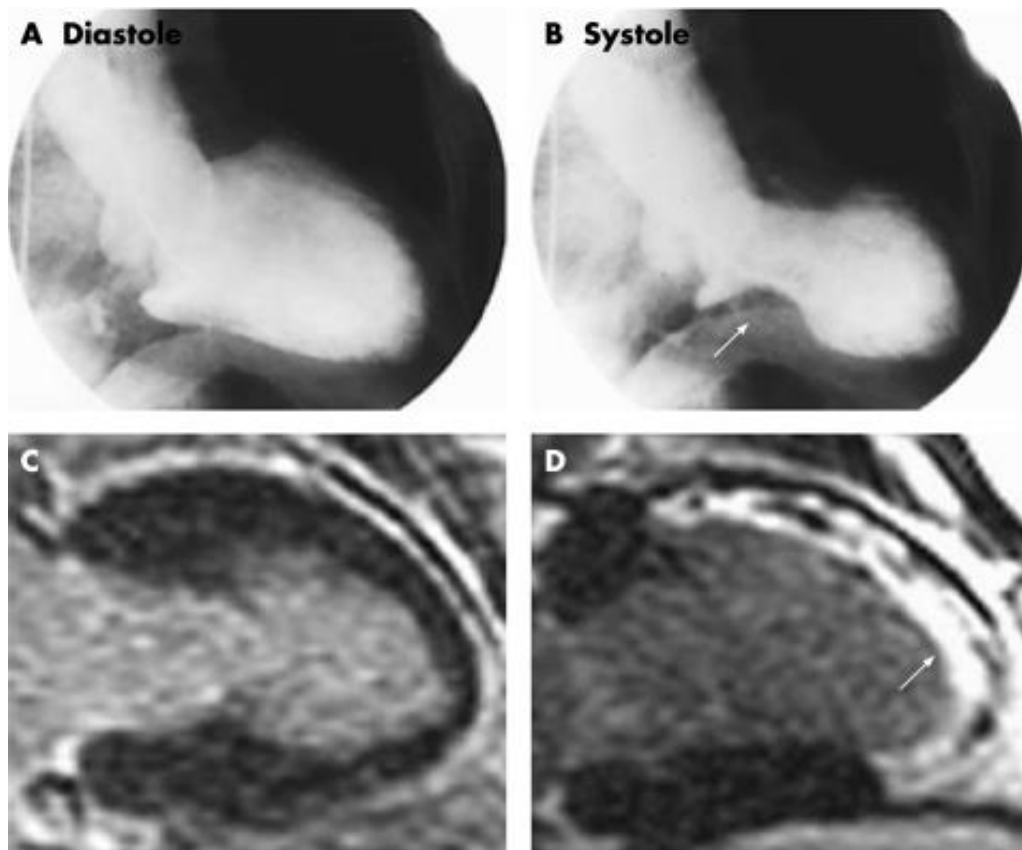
Ventriculographic assessment of cardiac function and magnetic resonance imaging (MRI) assessment of myocardial viability at admission in a patient with stress cardiomyopathy
